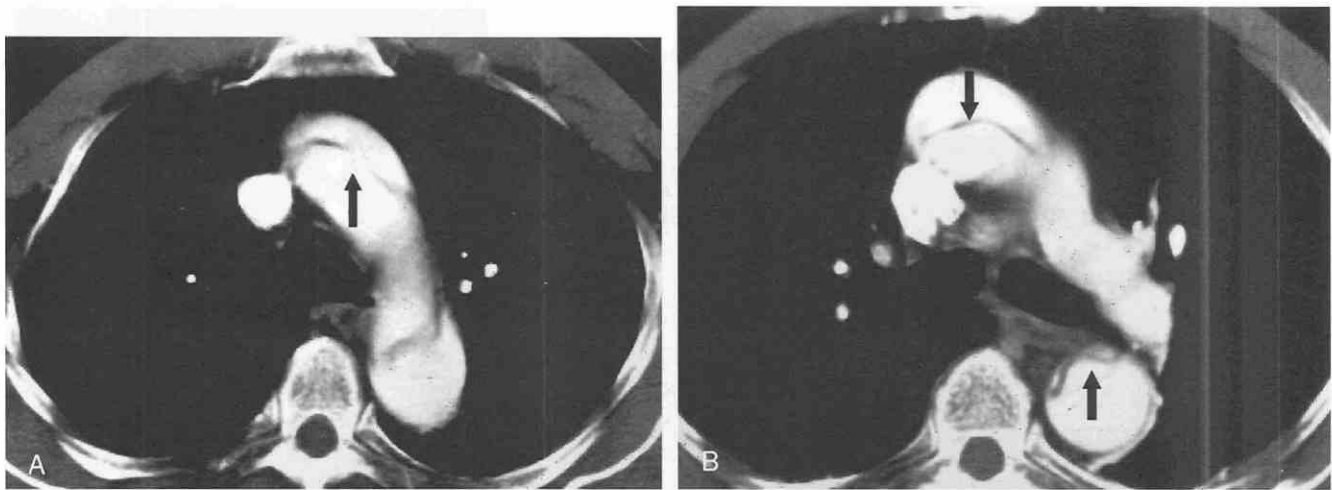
A, Axial CT scan shows type A aortic dissection with the dissection flap in the aortic arch (*arrow*). B, Axial CT scan at a level inferior to that of A reveals that the dissection flap involves the ascending aorta (*top arrow*). The true lumen is compressed anteriorly (*bottom arrow*).
